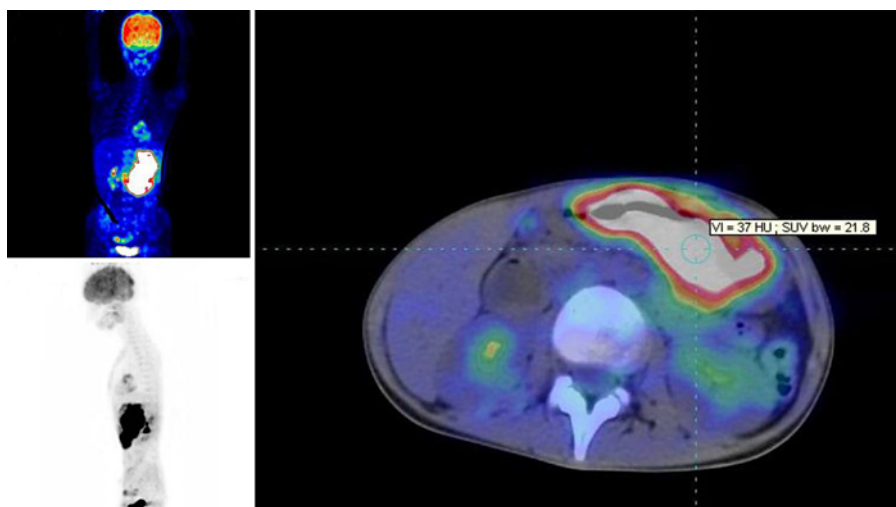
PET-CT scan showing pathological uptake of FDG in the stomach wall and lymph nodes.
